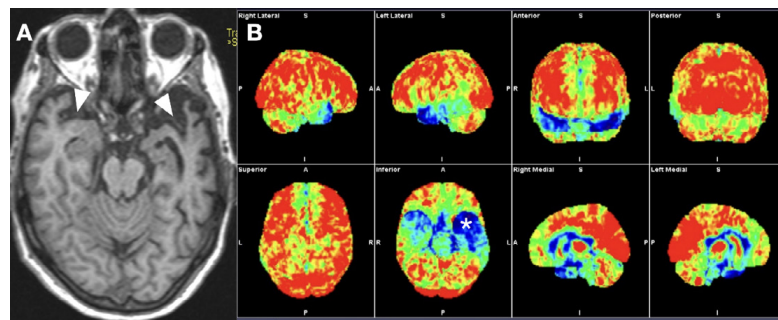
(A) Axial T1-weighted MR imaging in a patient with frontotemporal lobar degeneration (semantic variant) demonstrates asymmetric cerebral volume loss in the temporal lobes (white arrows) with knife-edge atrophy demonstrated on the left side. (B) 18F-FDG-PET demonstrates marked asymmetric hypometabolism affecting the frontal and temporal lobes, most marked on the left (white asterisk). Metabolism within the occipital lobes and posterior cingulate gyri is preserved.
